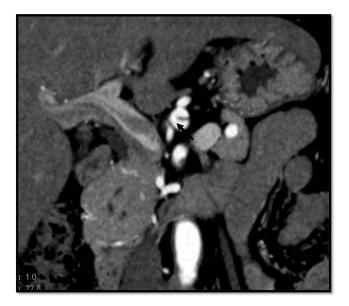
The CTA image of the distal side of CA. The contrast medium seems re-enter the false lumen and the common hepatic artery (black arrow).
